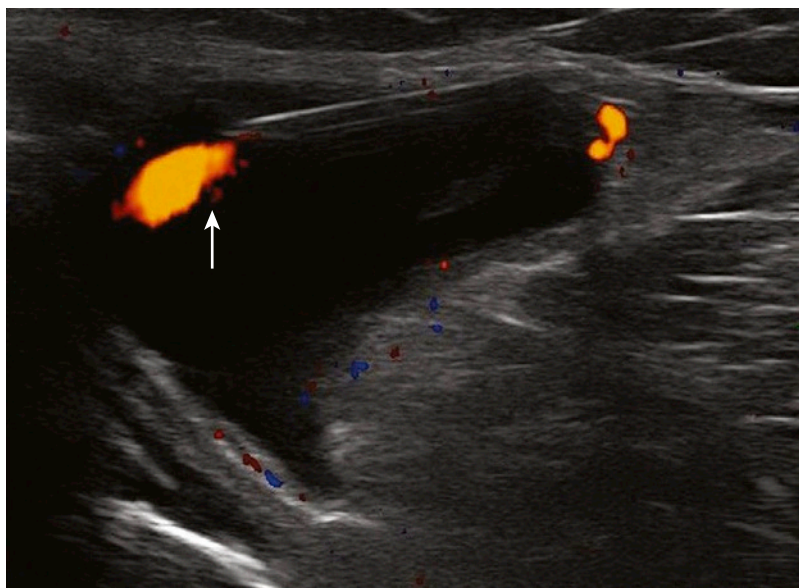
Air arthrography uses power Doppler imaging. The Doppler jet (*arrow*) appearing at the tip of the needle is caused by the injection of air into the fluid-filled cavity and facilitates the visualization of the needle. The Doppler signal in other areas of the image corresponds to increased blood flow caused by inflammation.
